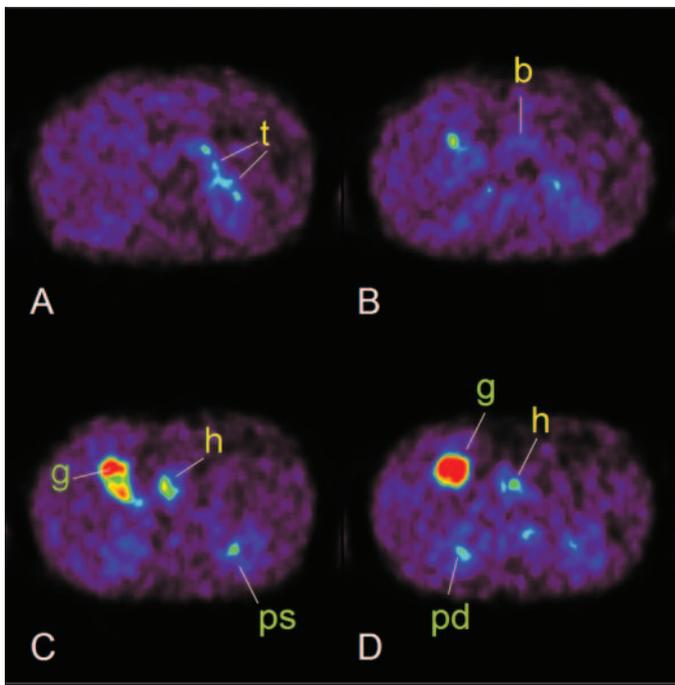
Axial [^{18}F]-DOPA PET views at four levels (A-D) showing pancreas and some other tissues with physiologically increased tracer uptake in a 5-year-old girl (patient 6) presumably having a diffuse form of hyperinsulinism of infancy. In A, the pancreatic tail (t) has maximum [^{18}F]-DOPA SUV of 3.4, while that of the body of pancreas (b) in B is 2.6 and of the head of pancreas (h) in C and D is 4.6. The gallbladder (g in C and D) has much higher uptake of tracer than pancreas in this case, where both kidneys (ps in C and pd in D) can be visualized as well. This case had the highest SUV_{max} ratio (1.4) among all classified as diffuse. Although a focus in pancreatic head cannot totally be ruled out, the negative PACS result, the absence of *ABCC8* mutation, and the good response to diazoxide treatment left us to withhold from surgery.
